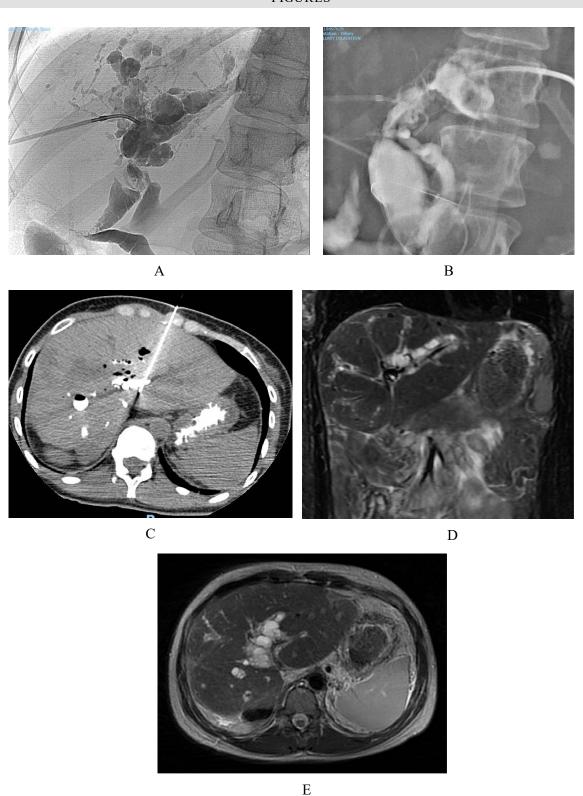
(case 1): A: Cholangiogram from right hepatic duct puncture showing bilateral and multiple stenoses and strictures (type C). Communication with the bowel is not clearly seen. B: Cholangiogram from left hepatic duction showing communication with bowel (path of wire). C: intra procedural CT showing the most suitable area of puncture in the left duct and targeting on CT. D and E: T2 weighted MRI showing diffuse dilatation of the intrahepatic biliary ducts in both hepatic lobes and the dilated biliary ducts demonstrated beaded appearance.
